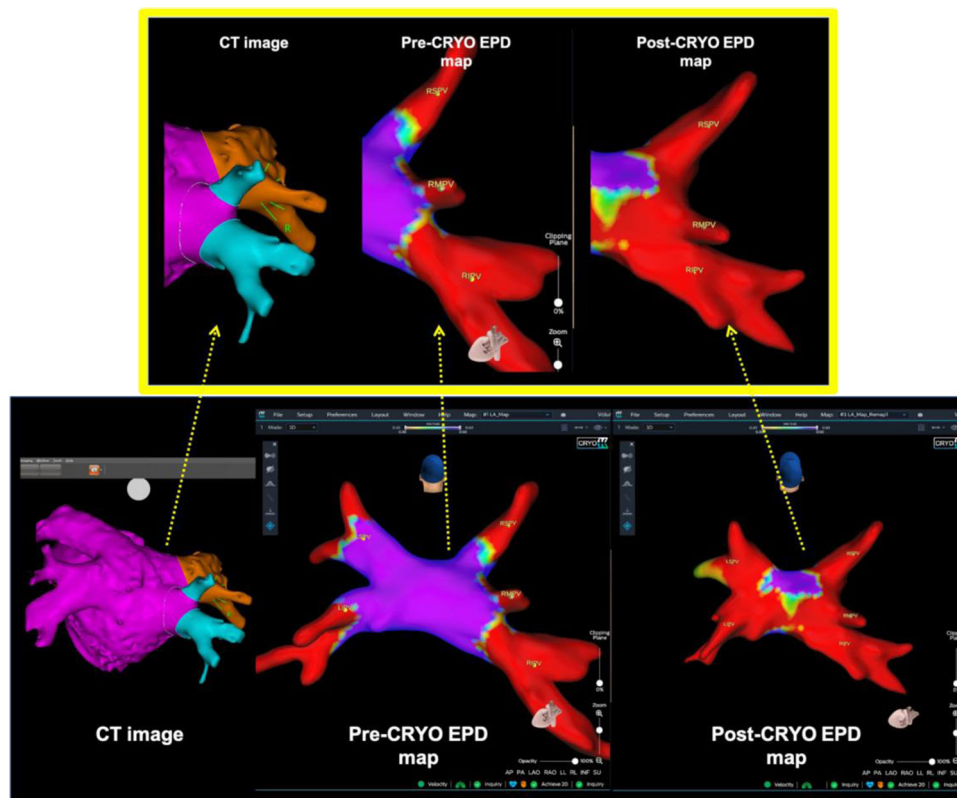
An example of disagreement regarding a right middle pulmonary vein anatomy. The CT demonstrated a superior branch to the right inferior PV while the KODEX-EPD system demonstrated a separate right middle pulmonary vein os. In addition, the pre-CRYO and post-CRYO anatomical map differed. The pre-CRYO map demonstrated a separate RMPV while the post-CRYO map demonstrated an early superior branch of the RIPV. CT, computed tomography; PV, pulmonary vein; RIPV, right inferior PV
